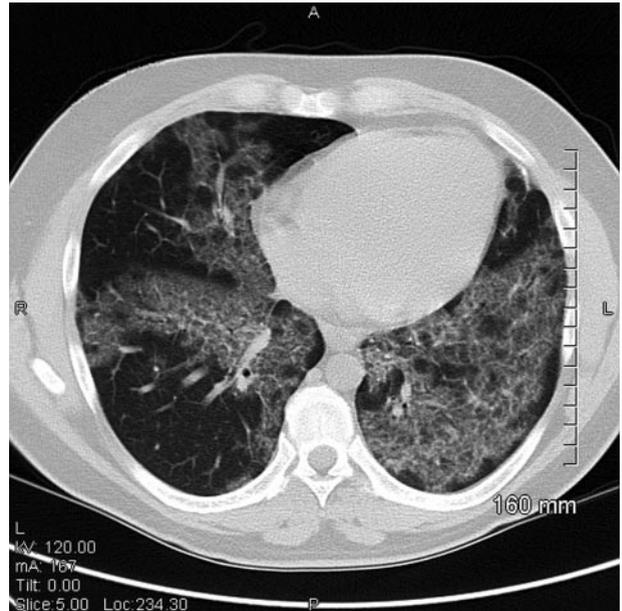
CT scan image of PAP. The classic CT scan features of PAP include patchy areas of ground glass with thickening of the interlobular septae. This combination of findings is commonly known as *crazy paving*.
